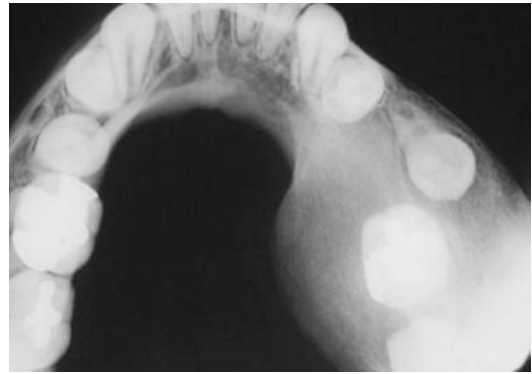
Occlusal radiograph demonstrating ground glass appearance and expansion of the mandible seen in fibrous dysplasia. (Reprinted with permission from Neville et al. [1])
